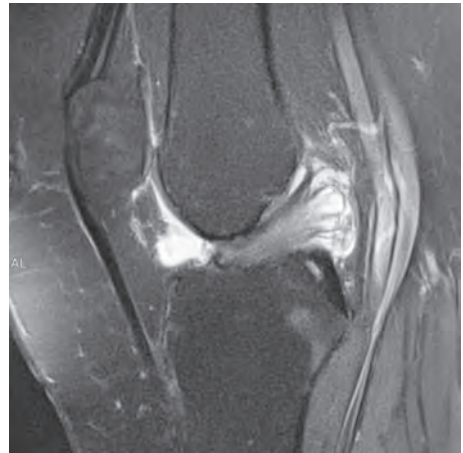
MRI showing a degenerative ACL cyst. Note that the anterior ligament bundle is clearly seen.
